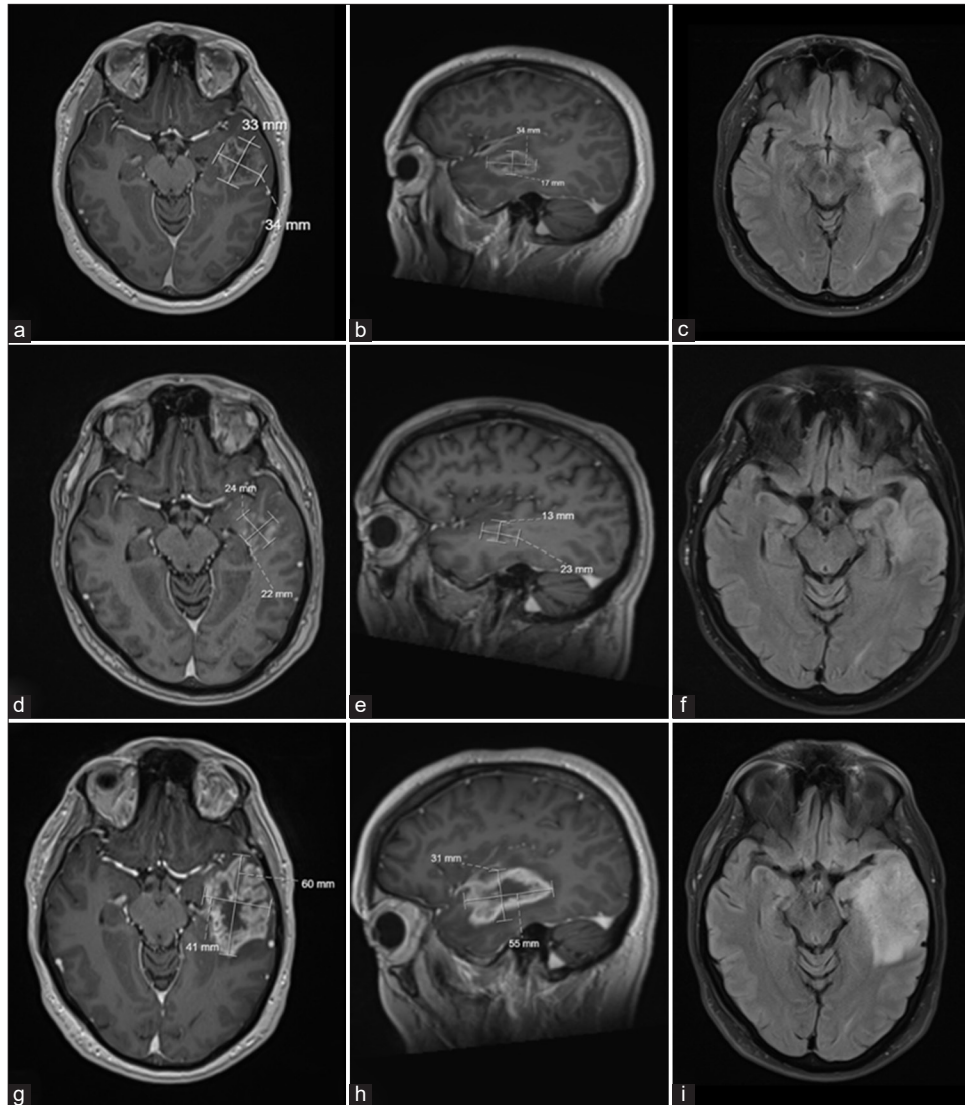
The size of the space-occupying lesion (SOL) was estimated using bidimensional measurements of an axial image. The diameter was measured using electronic callipers on each plane in two orthogonal directions. The plane with the greatest diameter was chosen. Sagittal images have been included for completion. (a) Axial and sagittal (b) postcontrast magnetic resonance imaging (MRI) brain T1 stealth on day 2 of admission demonstrating a SOL approximately $34 \times 33 \times 17$ mm in size. (c) Postcontrast MRI brain T2-fluid-attenuated inversion recovery (FLAIR) on day 2 of admission showed a left temporal lobe lesion associated with focal edema and associated mass effect on adjacent sulci. (d) Axial and sagittal (e) postcontrast MRI brain T1 stealth on day 23 of dexamethasone regimen demonstrating a decrease in size of the left temporal lobe temporal lesion, measuring approximately $24 \times 22 \times 13$ mm in size. (f) Postcontrast MRI brain T2-FLAIR on day 23 of dexamethasone regime. (g) Axial and sagittal (h) postcontrast MRI brain T1 stealth on day 64 of admission, 3 weeks following the cessation of dexamethasone. Now measuring $41 \times 60 \times 31$ mm, a large enhancing lesion with the appearance of a necrotic core in the left anterosuperior temporal lobe extending into the left basal ganglia. (i) Postcontrast MRI brain T2-FLAIR on day 64 of admission demonstrating high T2-signal vasogenic edema and local swelling.
